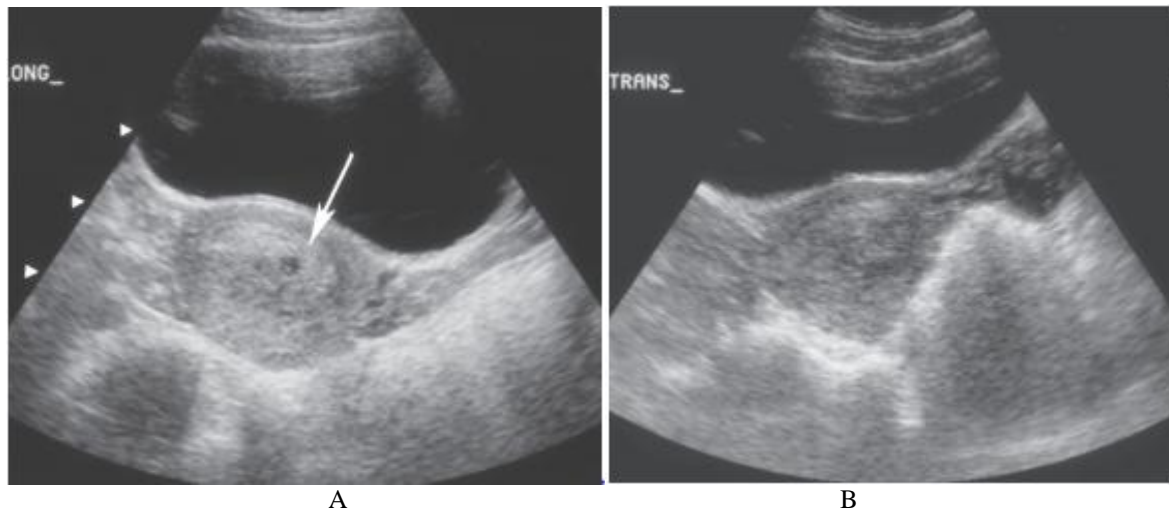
(A): Longitudinal ultrasound (transabdominal) image of the pelvis, showing echogenic areas filling the cavity of the uterus. (B) Transverse ultrasound (transabdominal) image of the pelvis, showing maintained uterine contour and no evidence of extension into the abdomen.
